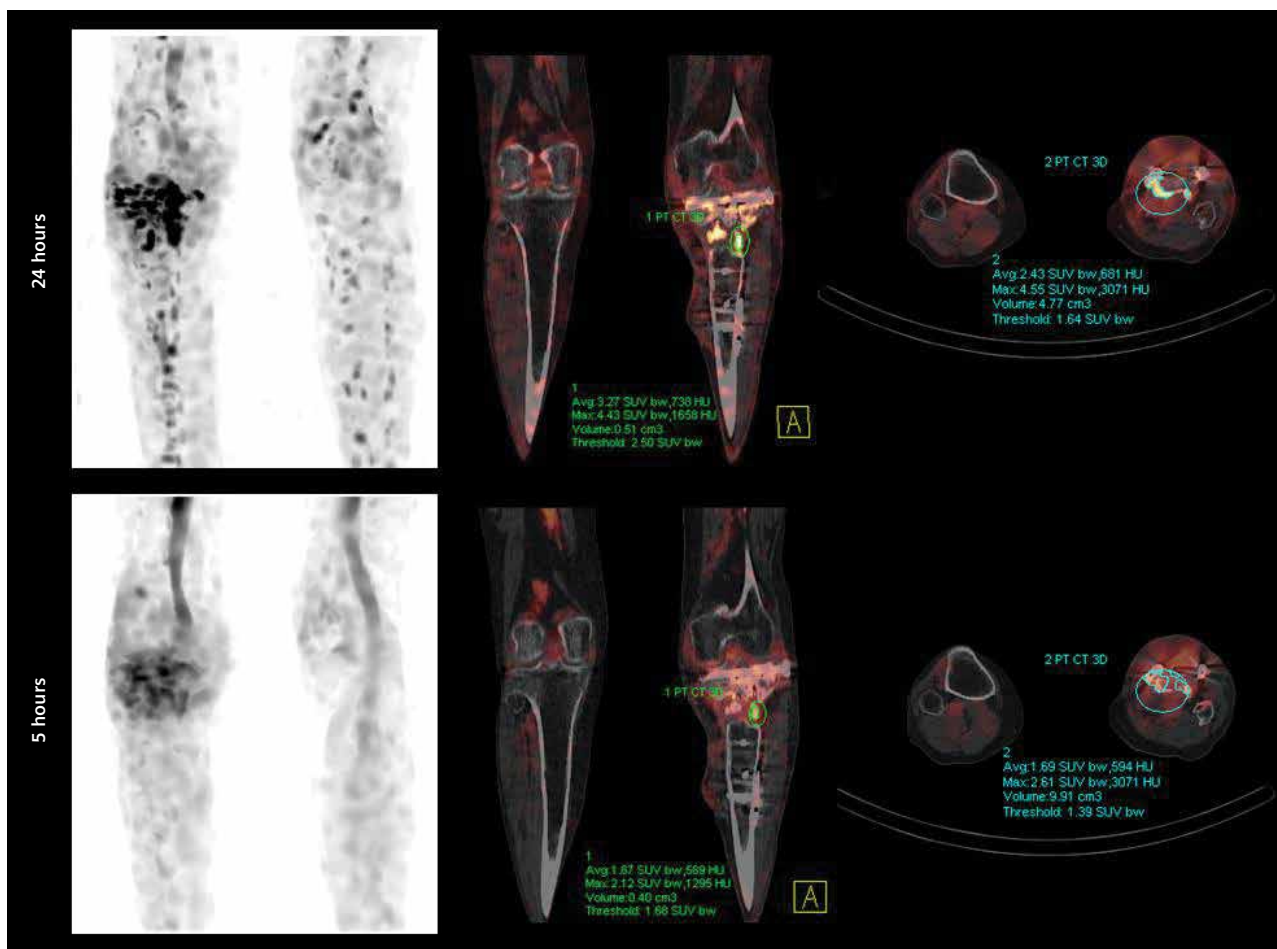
SUV_{max} comparison of uptake in the proximal end of the left tibia between 5- and 24-hour acquisitions shows a significant increase in SUV_{max} with time.
